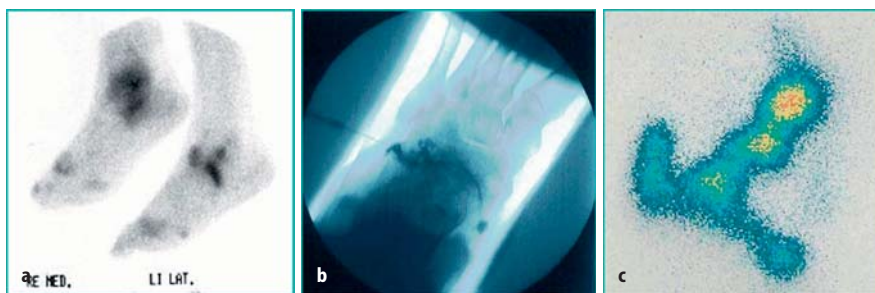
Patient with rheumatoid arthritis was submitted for RSO of the left ankle. a Soft tissue scintigram detected no inflammatory involvement in the ankle but in the talonavicular, subtalar and calcaneocuboid joint. b Arthrogram after injection in the calcaneocuboid joint. c Distribution scintigram demonstrating perfect distribution in all joints marked in the diagnostic scintigram (a)
